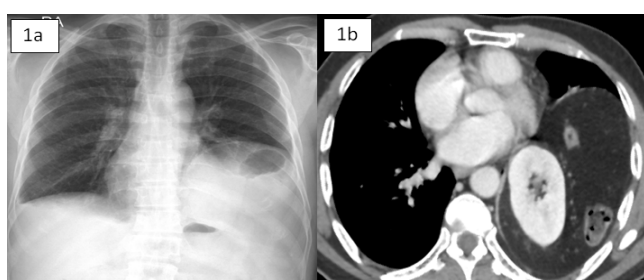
PA chest radiograph (figure a) shows large homogeneous soft tissue lesion with air locule in the left lower hemithorax silhouetting the left hemidiaphragm and causing mild contralateral mediastinal shift. Axial contrast CT of thorax (figure b) shows left kidney, splenic flexure of colon and omentum in left hemithorax up to level of heart.
